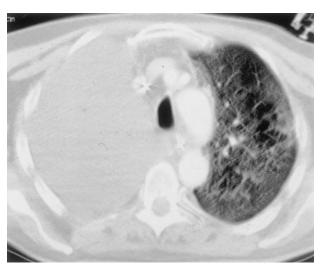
Computed tomography scan of patient 2 (section above the carina), showing reticular opacities, thickened septal lines, and an area of patchy consolidation. The computed tomography scan of patient 1 had a similar pattern of infiltrates.
